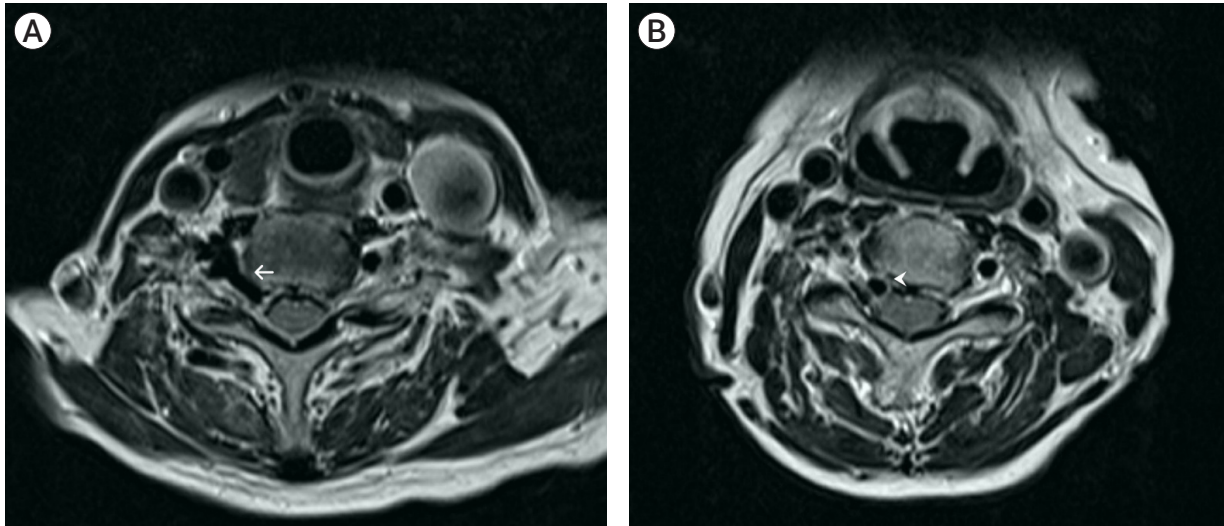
Axial T2-weighted cervical spine magnetic resonance shows abnormal flow voids on the right C5-6 (A) and C4-5 (B) intervertebral foramina. Abnormally dilated right C5-6 intervertebral vein is seen entering the right ventral epidural space within the vertebral canal (arrow). The right anterior internal vertebral venous plexus compresses the nerve root passing the C4-5 intervertebral foramen (arrowhead). However, the image does not show any deviation due to spinal cord compression or high signal intensity in spinal cord.
